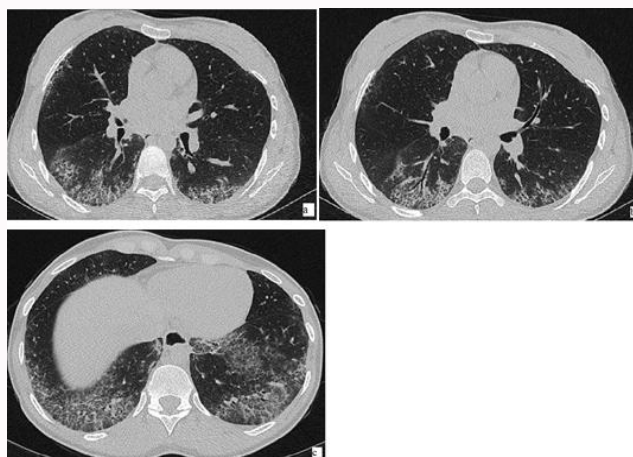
HRCT demonstrating honeycombing and traction bronchiectasis consistent with Usual Interstitial Pneumonia (UIP) ILD. Traction bronchiectasis is caused by the fibrotic lung pulling on the bronchi, causing irreversible dilatation.
